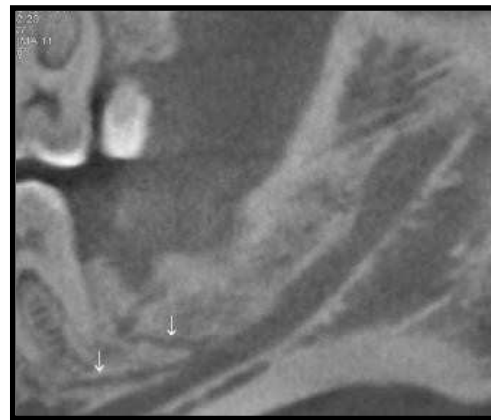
CBCT image shows canal type 5D (trifid canal type: two accessory canals of one dental and one forward canal type)
